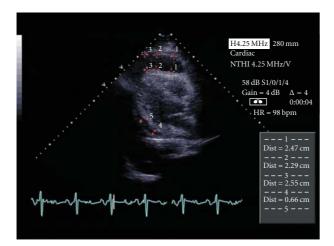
Echocardiographic image showing anterior and posterior pericardial effusion.
